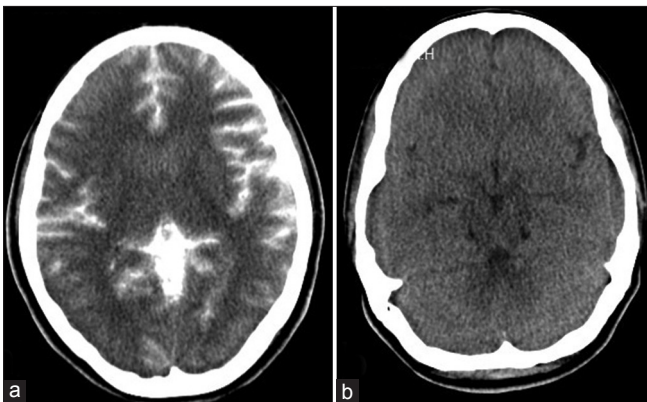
Computed tomography of brain revealed diffuse subarachnoid contrast throughout the brain (a) A repeat computerized tomography scan after 72 h showed complete clearing of the contrast (b)
